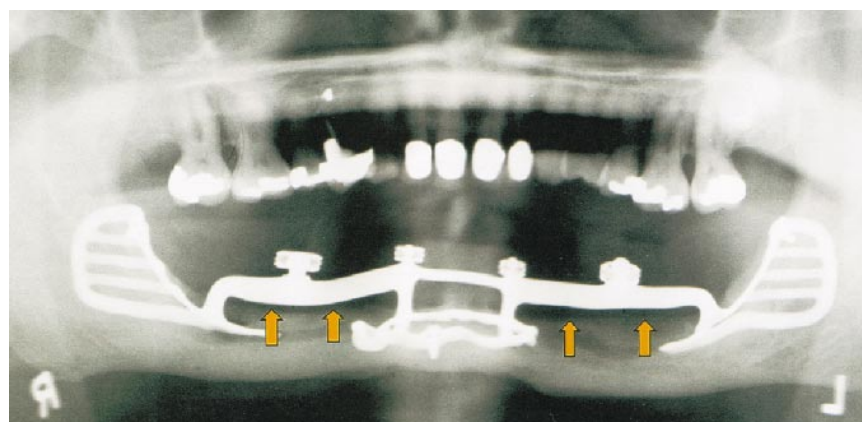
Panoramic radiograph of the patient on March 1, 1999. Arrows denote bone regeneration along superior aspect of the mandible.
